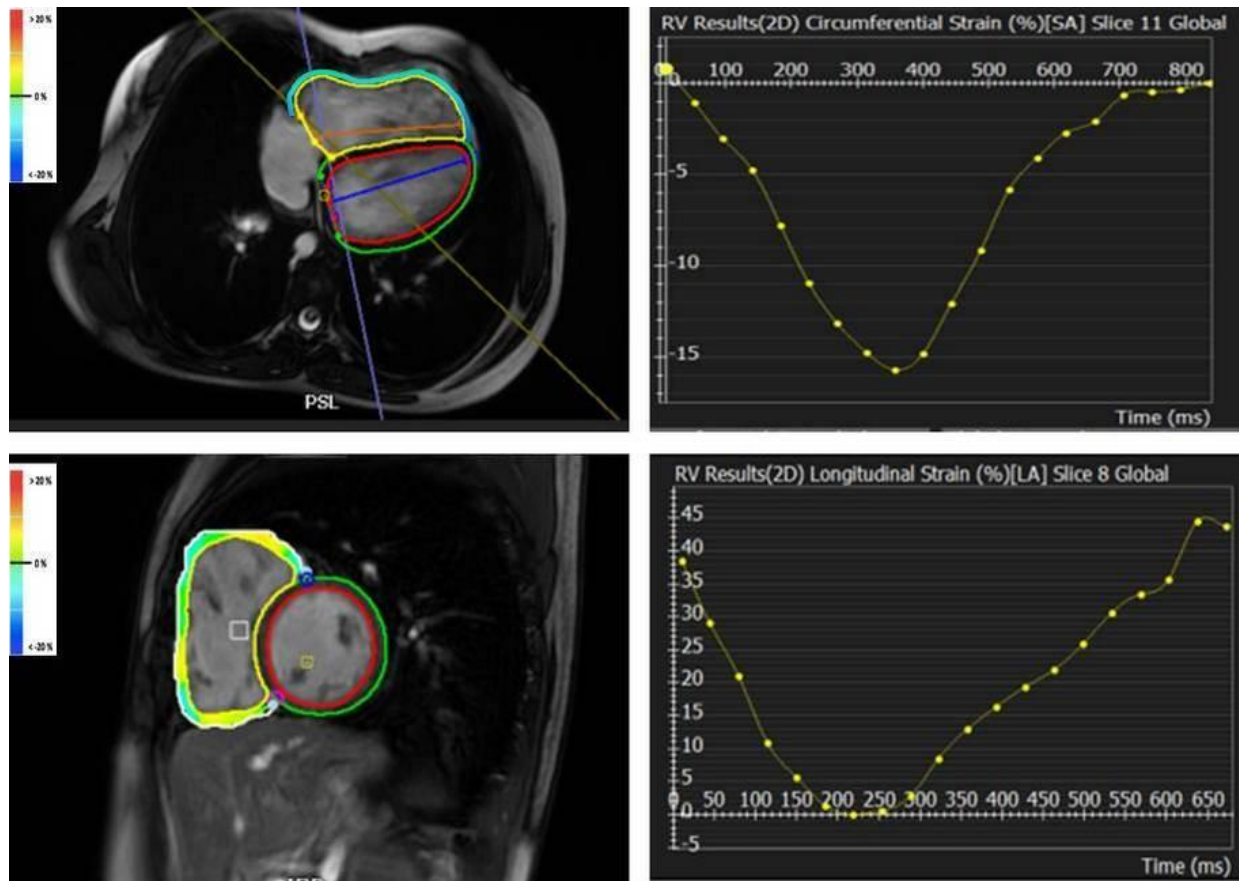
8: Magnetic resonance imaging colored strain analysis of the left ventricle. A four-chamber cine steady-state free precession sequence (upper-left) provides the radial strain curve (upper-right), and a short-axis cine steady-state free precession sequence (lower-left) provides the circumferential strain curve (lower-right). The green line represents the outline of the right ventricular epicardium, while the red line represents the outline of the right ventricular endocardium. The yellow lines in the graphs (left-upper, left-lower) correspond to strain measurements of the right ventricle.
